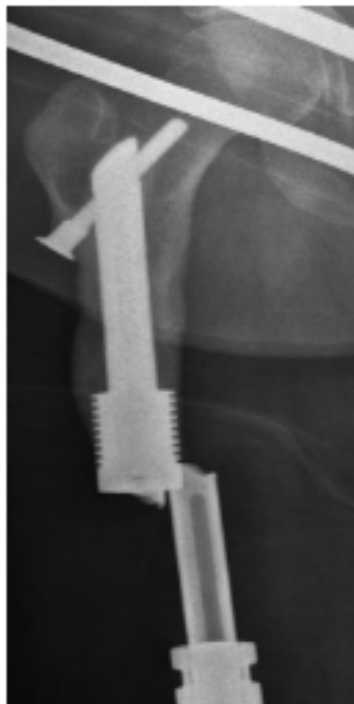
Radiograph of a broken femoral component in a female patient aged 17 years without signs of aseptic loosening 169 months after surgery.
